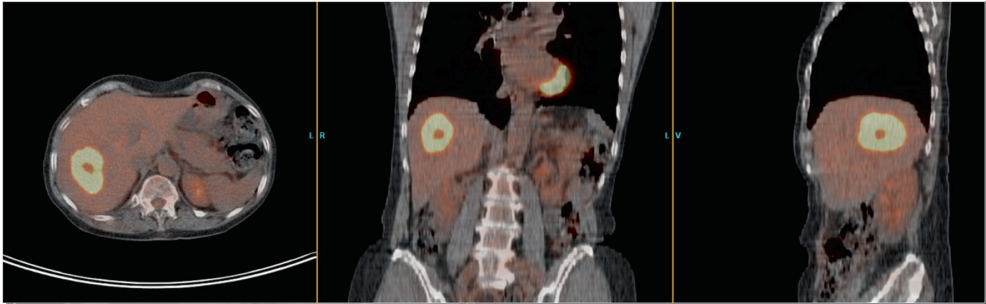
FDG PET with low dose CT showing a high FDG uptake in the solitary liver metastases, with central necrosis.
